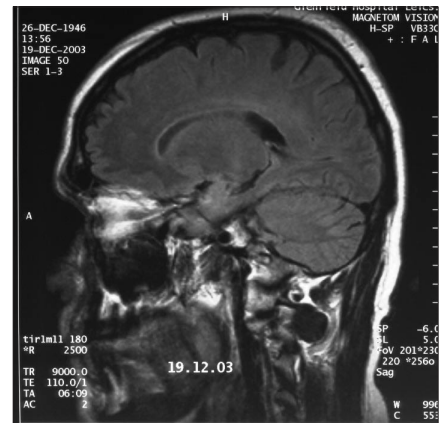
Follow-up magnetic resonance imaging scan showing complete resolution of the hyperintense areas seen on the initial scan.
